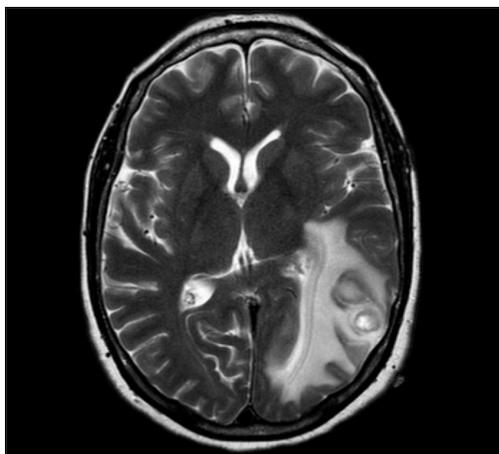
MRI showing a solitary metastasis in the left parieto-occipital lobe with peritumoral edema
